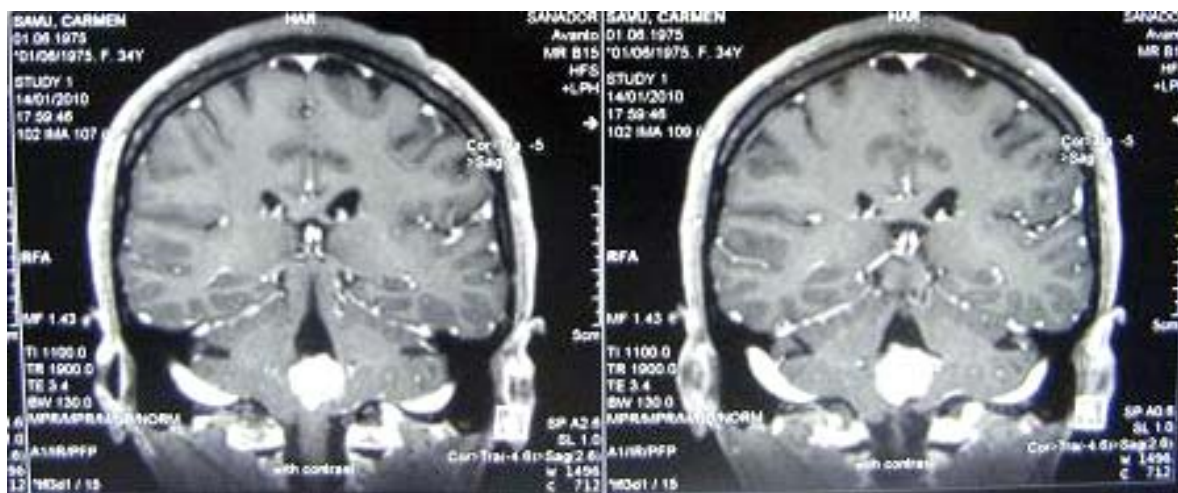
Preoperative MRI-scan (coronal incidence)
